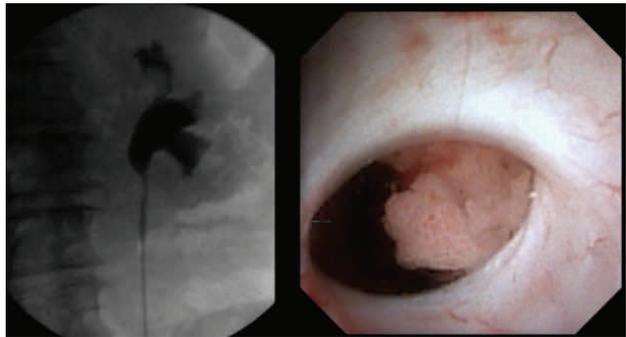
A broad-based sessile lesion is noted in the upper pole papilla on MRI and pyelogram. Inspection revealed a bulky, papillary tumor.
